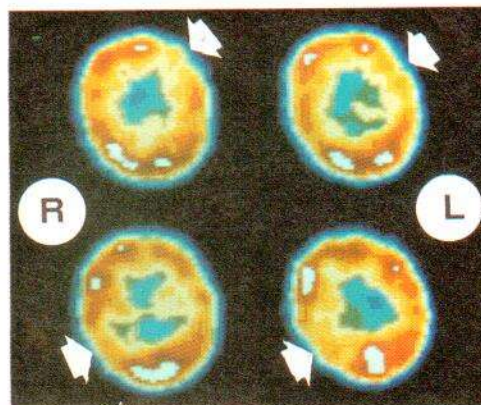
One-year-old girl with reovirus encephalitis which could not be distinguished from Herpes simplex encephalitis by clinical, EEG and CT findings. SPECT showed modest hypoperfusion in right frontoparietal and left frontotemporal areas, which both became normal within three months. Isolation of reovirus from sample of faeces taken six days after onset verified virological diagnosis.
